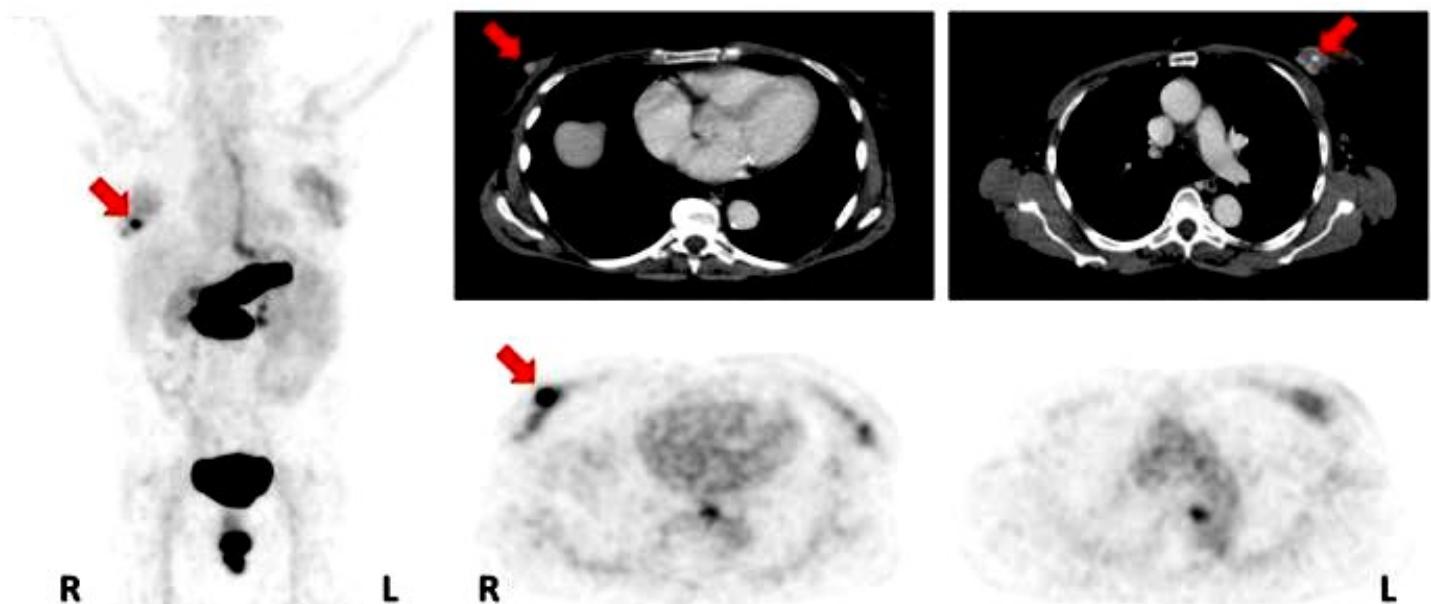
74-year-old patient with a bilateral tumor with an ER/PR-positive tumor on the right side (PET-positive) and an ER/PR-negative tumor on the left side (PET-negative). Maximum intensity projection (left); CT (upper row); ^{68}Ga -RM2-PET (lower row); primary tumors indicated by red arrows (4).
